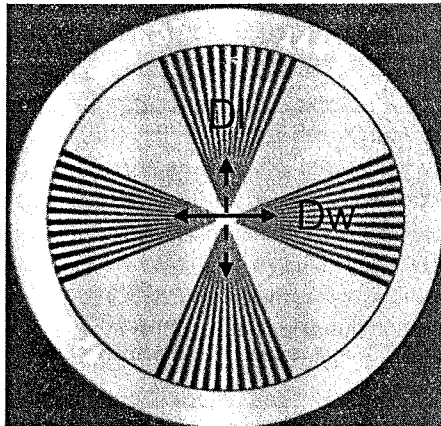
Radiograph for finding the focal spot size by using star technique. The dark arrow shows the widest blur distance along cathode-anode direction (Dw), the dashed arrow shows blur distance along transverse direction (Dl)
